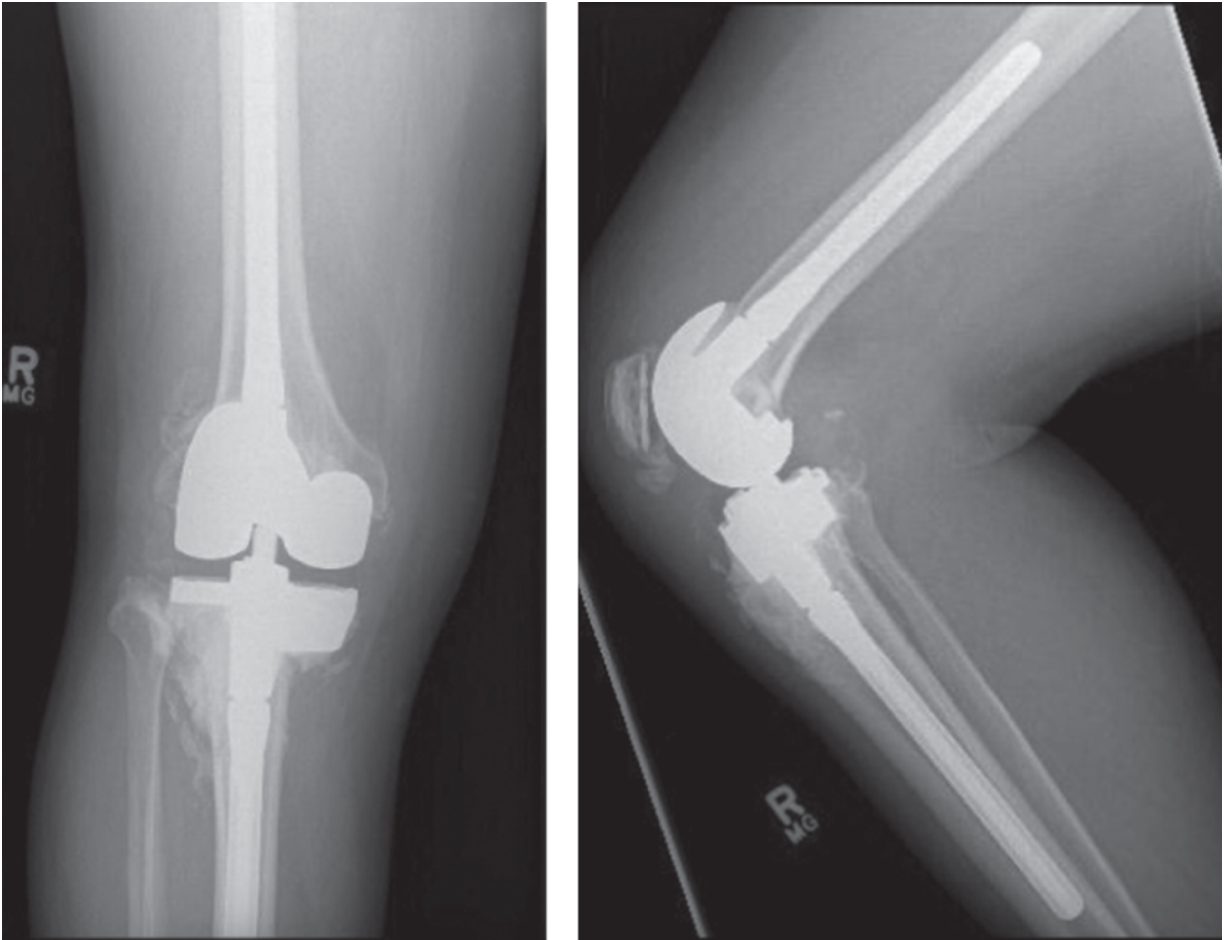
Postoperative radiographs.
